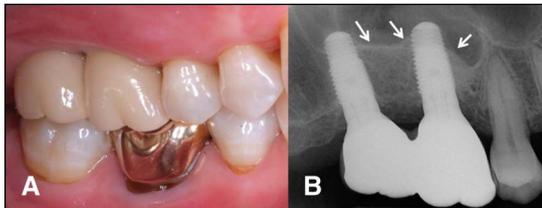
Intraoral photo and periapical radiogram. A, A porcelain-fused metal crown bridge was connected with the implants. B, A periapical radiogram was taken at the prosthesis connection. Newly formed sinus floor was observed (arrow).
